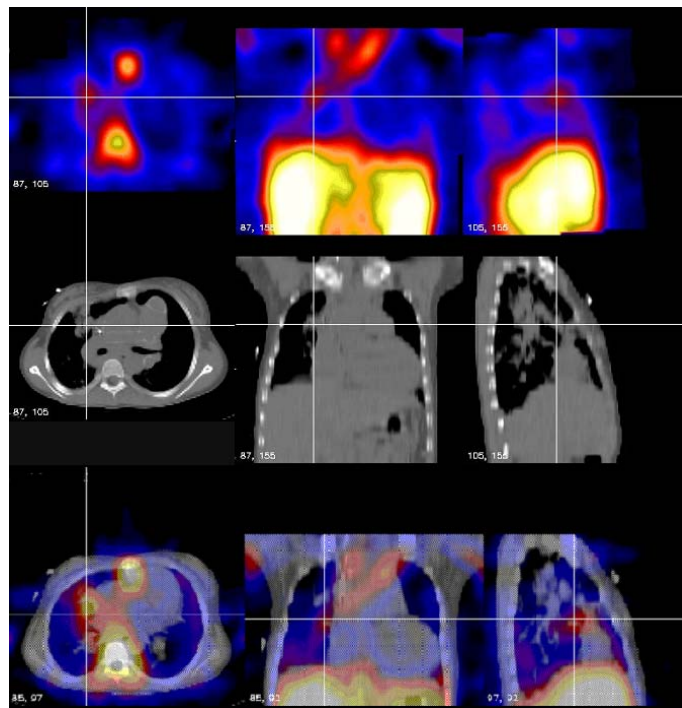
Registered gallium-67 SPET and CT showing the focal localization of uptake. The fusion of images confidently located the gallium-67 avid lesion outside of lung tissue and within a prosthetic vascular conduit. SPET (top) and CT (middle) images of three orthogonal sections (left to right: transverse, coronal and sagittal) are displayed with a linked cursor. Also shown is the fused display (bottom).
